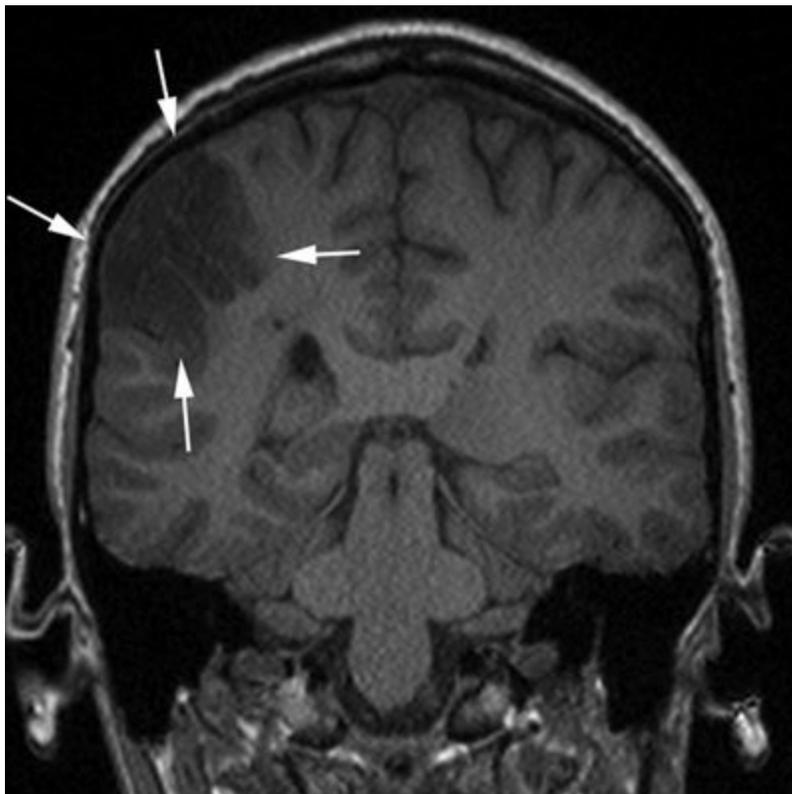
Dysembryoplastic neuroepithelial tumor: Coronal MPRAGE image from MRI without gadolinium in a 13-year-old girl with a 1-year history of left arm somatosensory progressing to dialeptic seizures shows a cortical lesion involving the right inferior parietal lobule characterized by multiple cystic structures, gyral broadening, and mild inner table scalloping (arrows).
